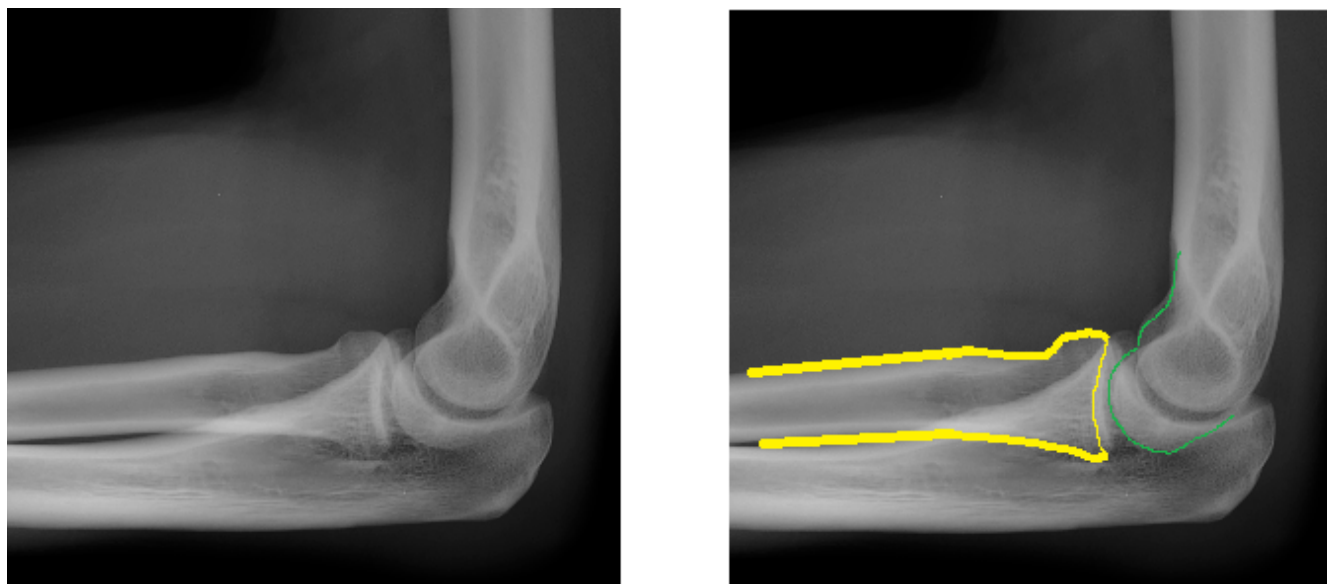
Radiograph of a normal elbow, left, with annotation on right showing the radius (yellow) articulating with the capitellum of the humerus (green). (Modified from Wikipedia <http://bit.ly/203iaNm>)
